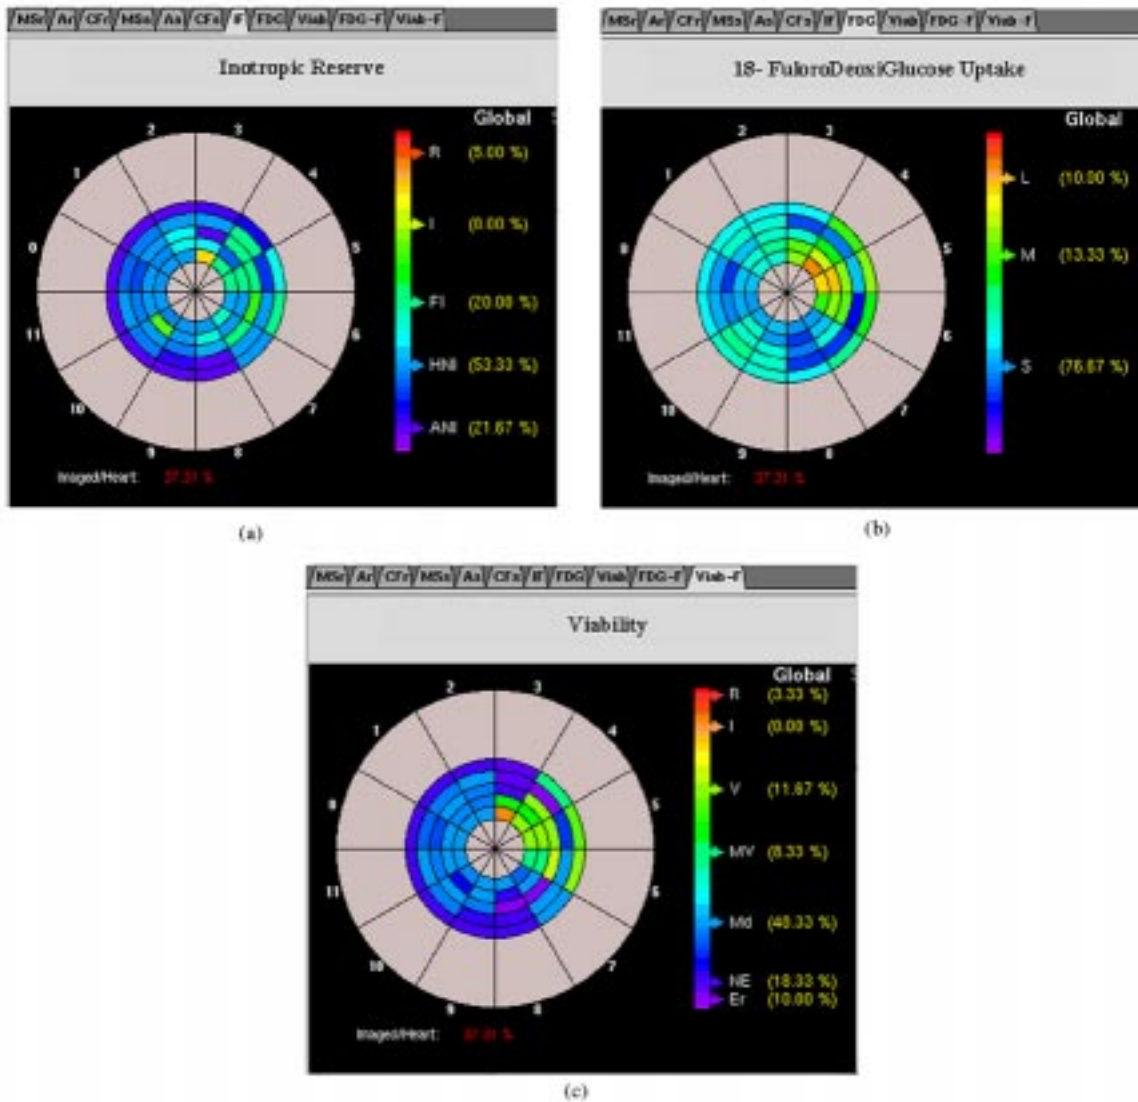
CAD output for a patient with a severe myocardial infarction. The large majority of sectors showed a very poor (a) *IR* and (b) *FDG*-uptake polar map. Only the septal wall showed metabolic activity. (c) Viability polar map. The CAD system indicates only 12% of the imaged heart as viable and 8% as metabolic viable. Therefore, this patient was not considered a candidate for reperfusion but for cardiac transplant.
